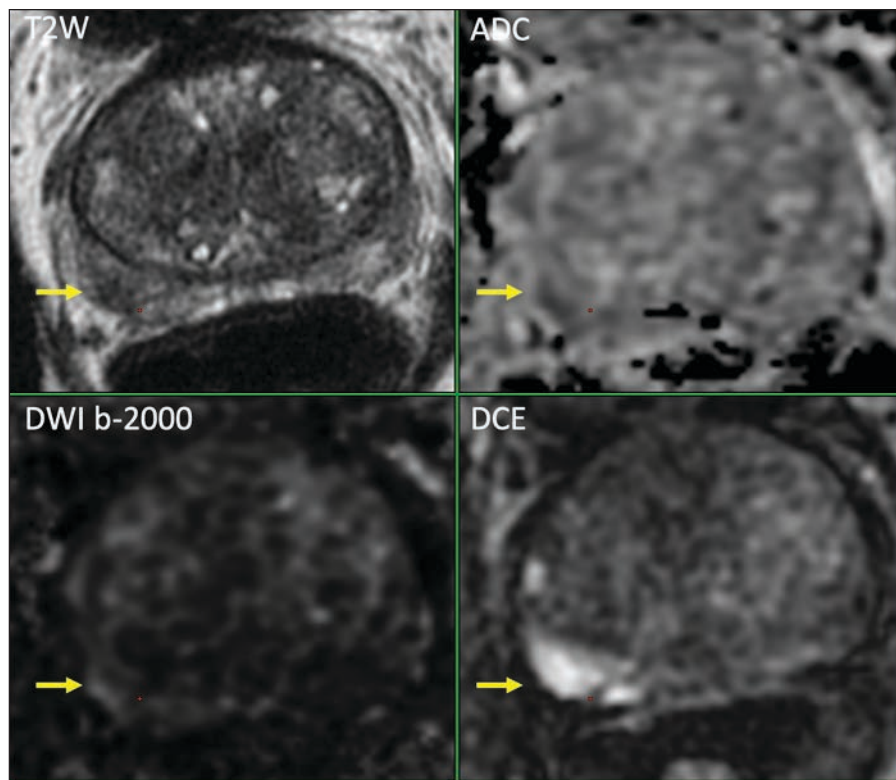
DCE-MRI adds value in some PI-RADS 2 scores in non-contrast MRI. 71 year-old man, cT1, PSA 8.2 ng/ml, PVMRI 72 ml, PSAD 0.12 ng/ml², primary diagnosis. In the right peripheral zone a lesion of 13-20 mm with heterogeneous but focal enhancement on DCE, barely identifiable on T2W or DWI/ADC. Final score was PI-RADS score 4 (upgraded 3+1) (T2W:3, DWI/ADC:3, DCE:+), indicating targeted biopsy. Without DCE this lesion would not have been identified. Two MRI-directed fusion biopsies revealed Gleason score 3+4=7 (ISUP grade 2) with cribriform / intraductal growth in both biopsies.
